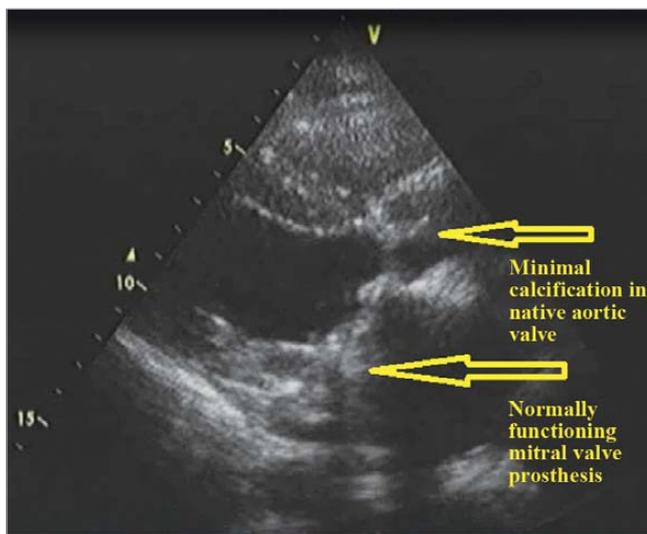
Echocardiogram showing very minimal aortic valve calcification.
